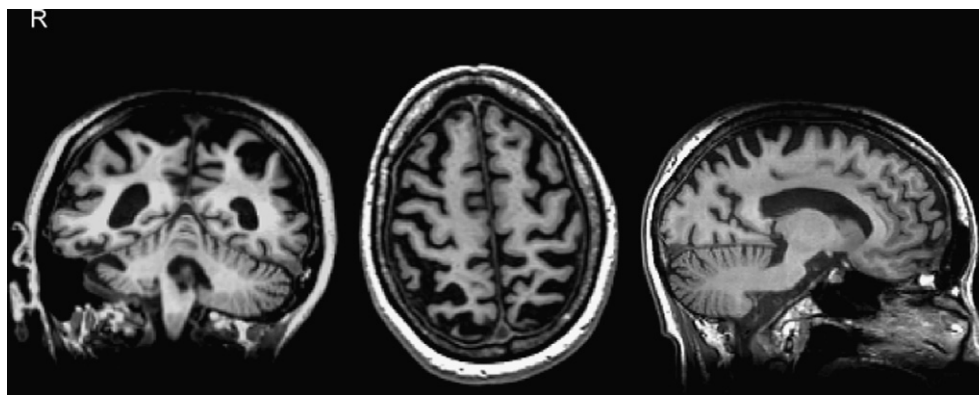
Native high-resolution structural MRI of the PCA patient. Note the bilateral posterior brain atrophy.
